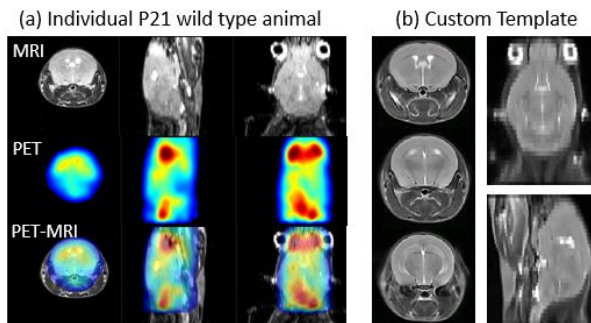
(a) T2 weighted MRI, PET, PET overlaid on MRI. (b) Sagittal, coronal and three axial views of a common template generated iteratively using T2 weighted images.
